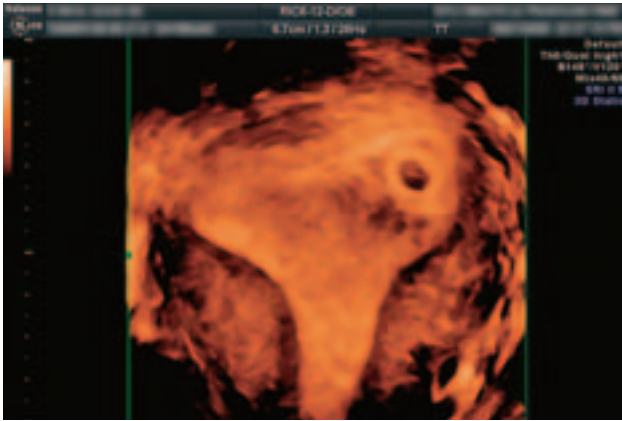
2D and 3D power Doppler image of five weeks of the pregnancy. Small gestation sac is seen, surrounded with developing vascularisation.
